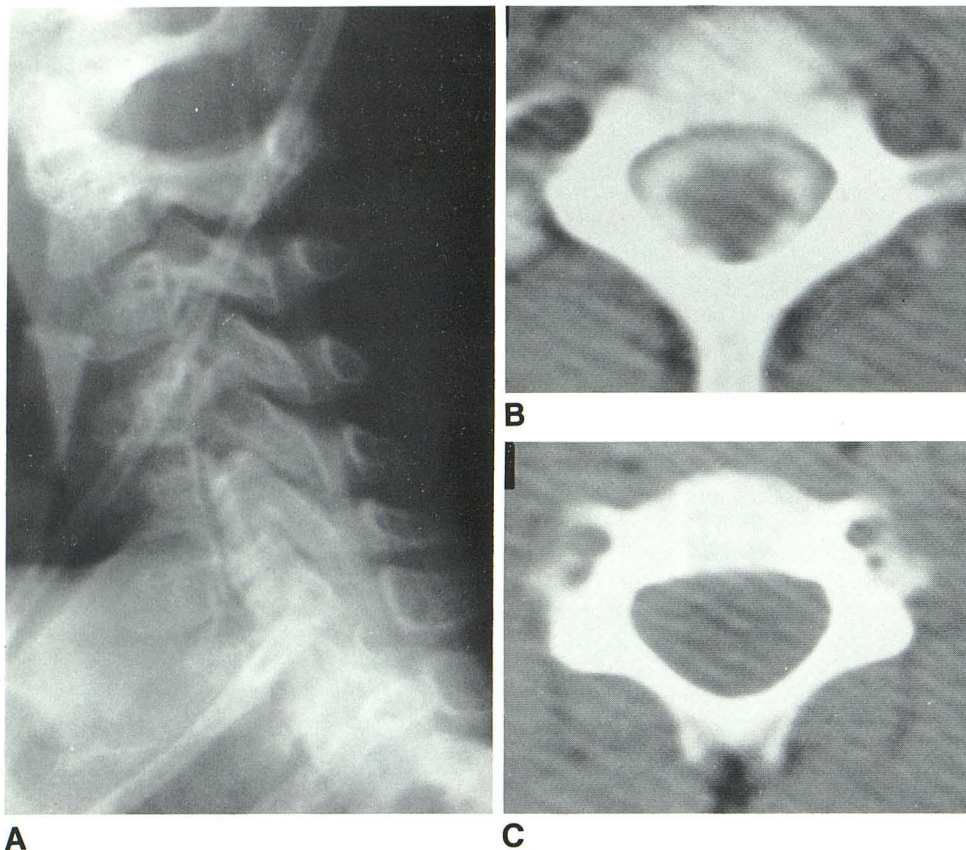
3½-year-old girl with subtotal removal of medulloblastoma. A, Lateral myelogram. Expansion of cord with complete obstruction of cranial flow of metrizamide. B, CT scan at C6–C7. Nodularity on cord surface. C, At C4. Complete obliteration of subarachnoid space from extensive cloaking of surface of cord with tumor.
